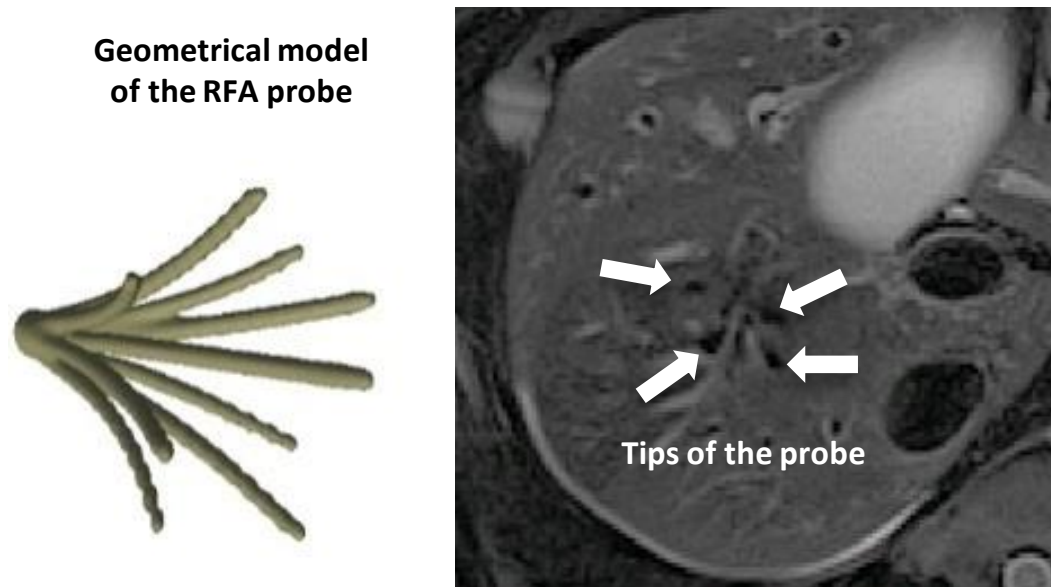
(*Left*): Mesh model of the probe with the 9 tips derived from a CT image of the probe only; (*Right*): Anatomical MRI with the MRI-compatible probe implanted in the liver. Four tips of the probe are visible.
